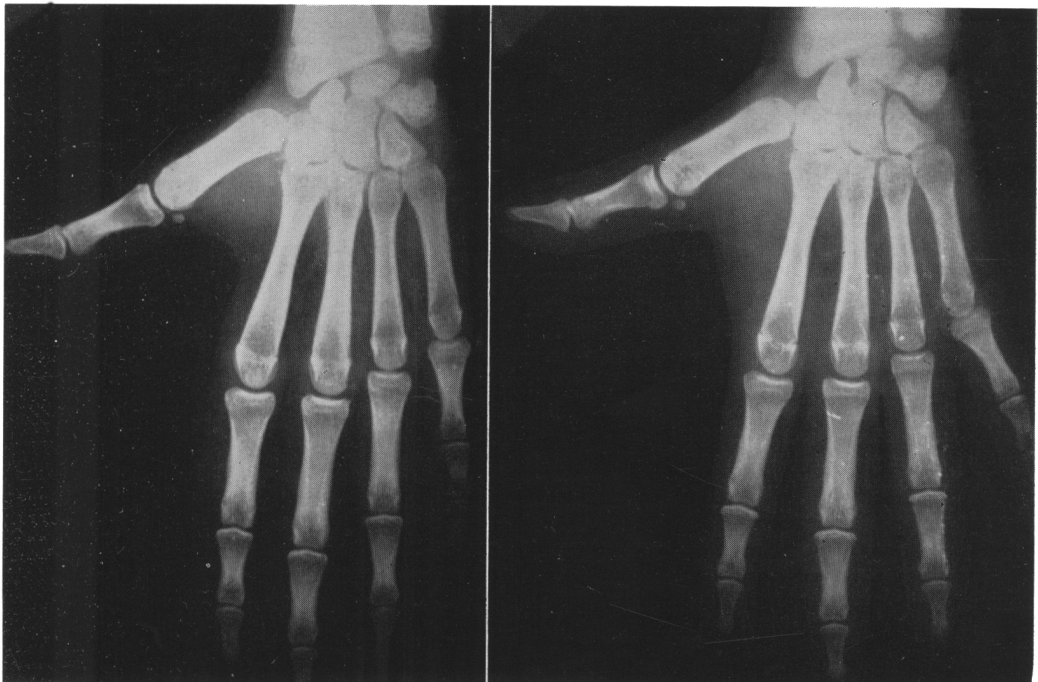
Comparative roentgenograms of hands and wrists of the twins at age 12 1/2 years. Twin No. 1, left; Twin No. 2, right. Maturation level consistent with chronologic age
